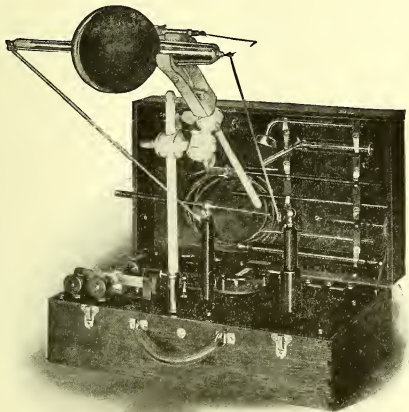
From this outfit can be obtained all of the modalities delivered by the large Rühmkorff coil except the ultraviolet light. However, it is not possible to transform as great a volume of energy in the small outfit, but there is sufficient for local application with vacuum electrodes, local D'Arsonvalization, effluve, spark, etc. The small outfit also gives satisfactory results in X-Ray work, and it possesses the advantage that it can be taken to the patient's bedside, and for the above work is comparatively inexpensive. The advantage of the office cabinet is that it furnishes large amperage for general D'Arsonvalization, and for the auto-condensation couch and for auto-conduction.
